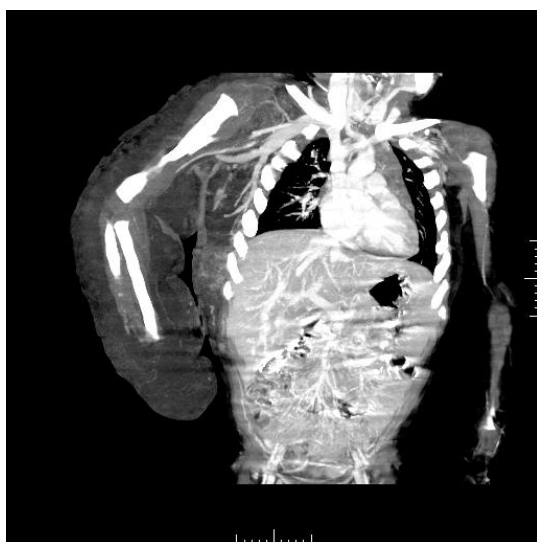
CT Angiography coronal reformatted image showing overgrowth of soft tissue of right upper limb extending up to involve the lateral thoracic wall and multiple dilated varicose veins in the right upper limb and lateral thoracic wall involving the superficial venous system.
